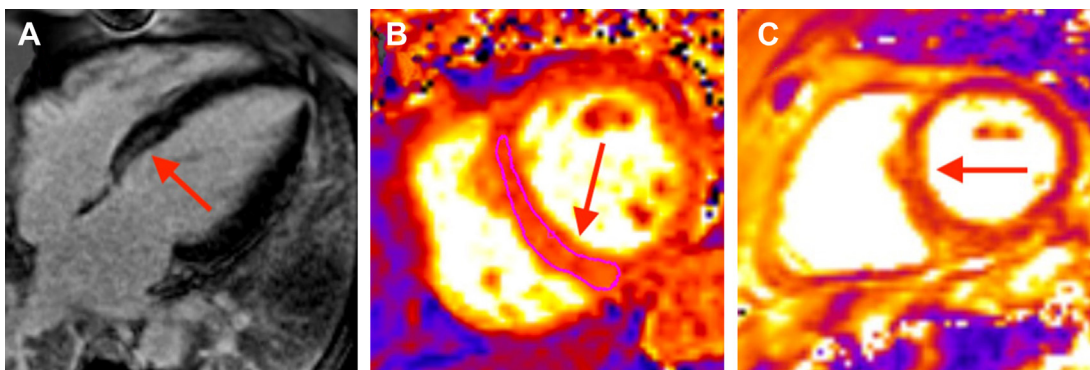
Representative images of (A) late gadolinium enhancement, and elevated (B) myocardial native T1, and (C) myocardial native T2 in a patient with suspected targeted cancer therapy (TKI) cardiotoxicity, as visualized by cardiac magnetic resonance imaging. Red arrows in panels (B) and (C) indicate areas of elevated T1 and T2, respectively; the pink outline in panel (B) denotes a region of interest (ROI) in the septum.
